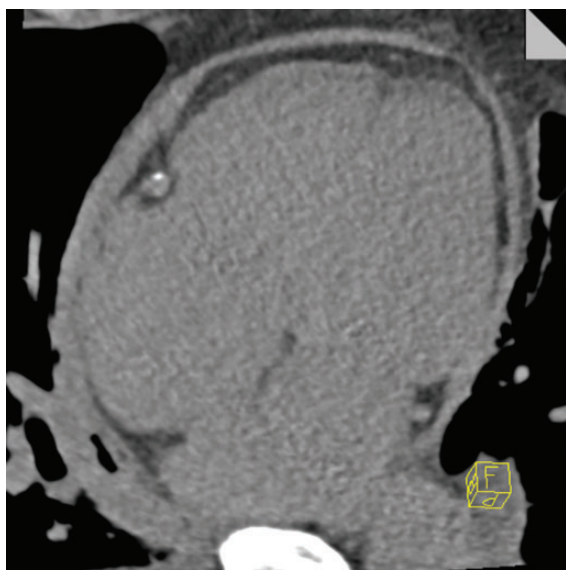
Thickened pericardium—without calcification—in a non-contrast CT acquisition of a patient with constrictive pericarditis.
